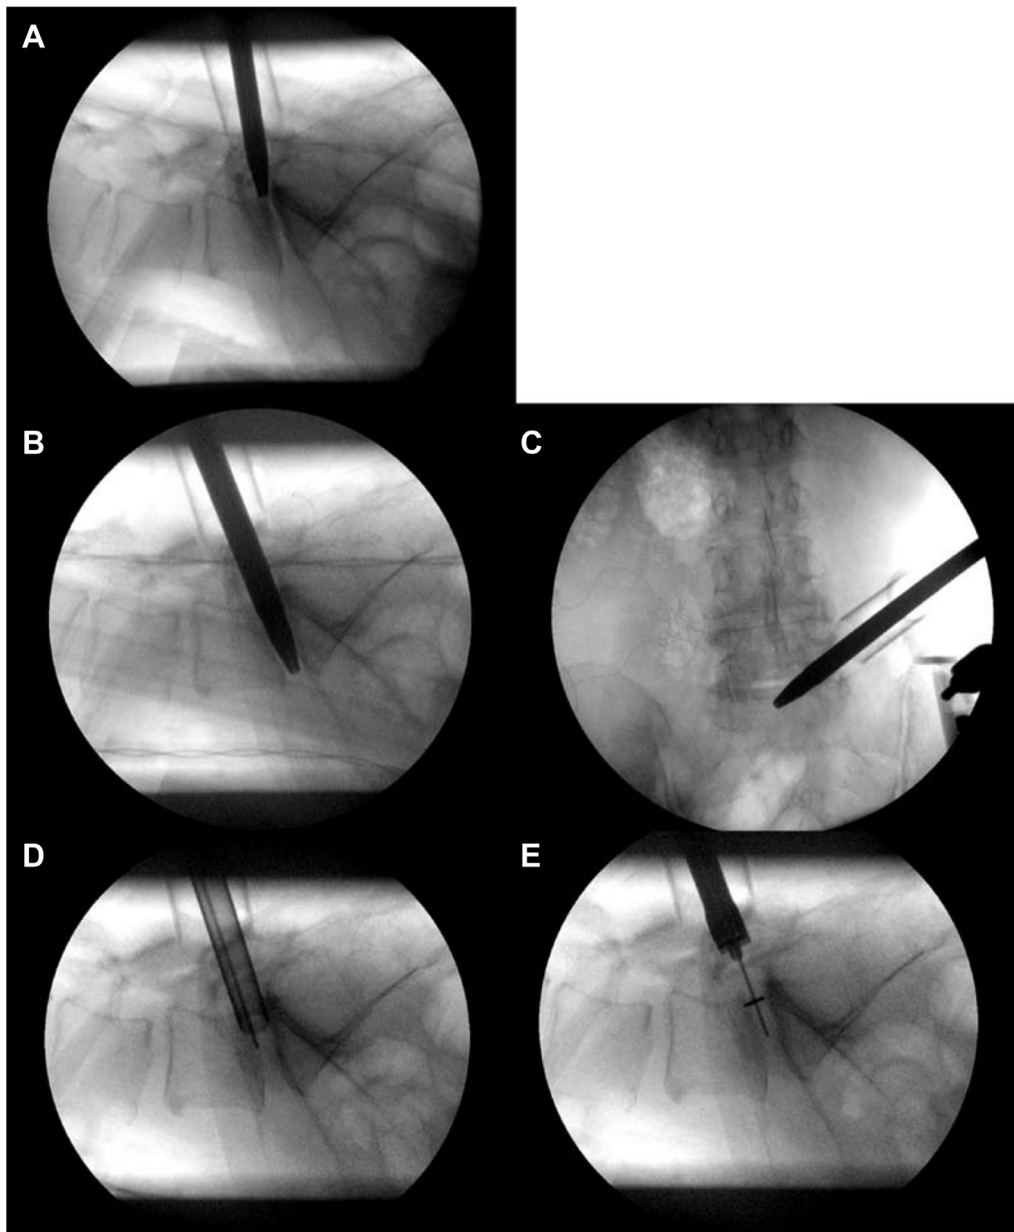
X-ray transoperative A. Lateral view: tubular retractor with endodiscal dilator. B and C. Endodiscal dilator insertion, lateral and AP view. D. Endodiscal cannula with K-wire insertion. E. Cage insertion with K-Wire.
